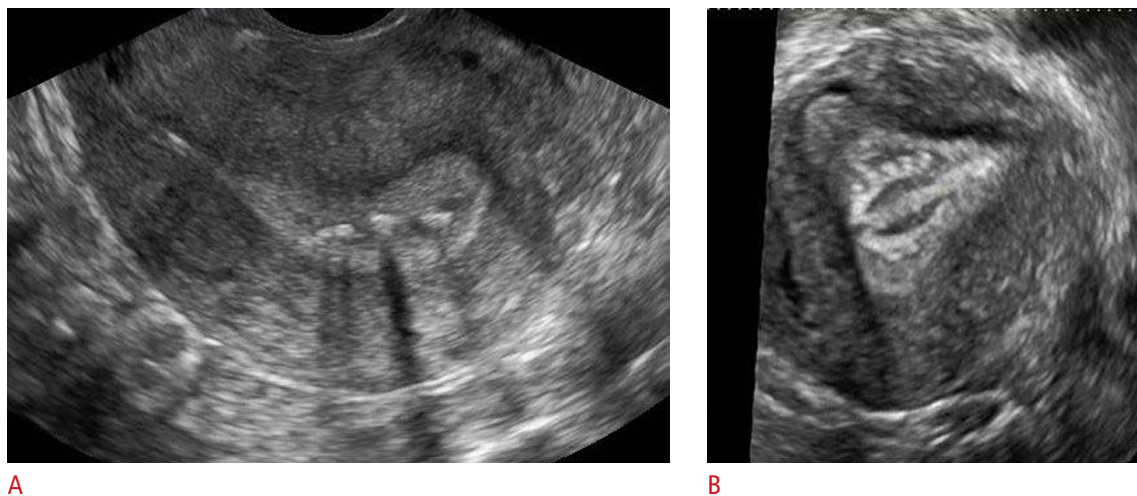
A malrotated intrauterine device (IUD) (Multiload) on two-dimensional (2D) ultrasonography and three-dimensional (3D) ultrasonography.
